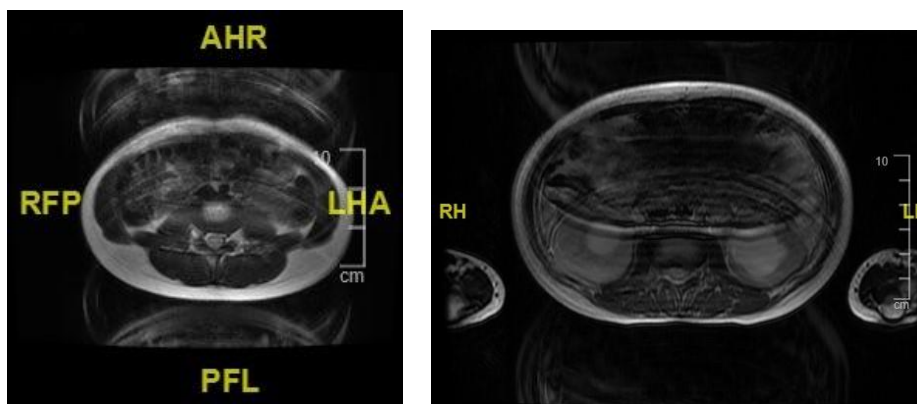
Axial T2-weighted images in a paediatric abdominal imaging. Aliasing artifact can be observed.
